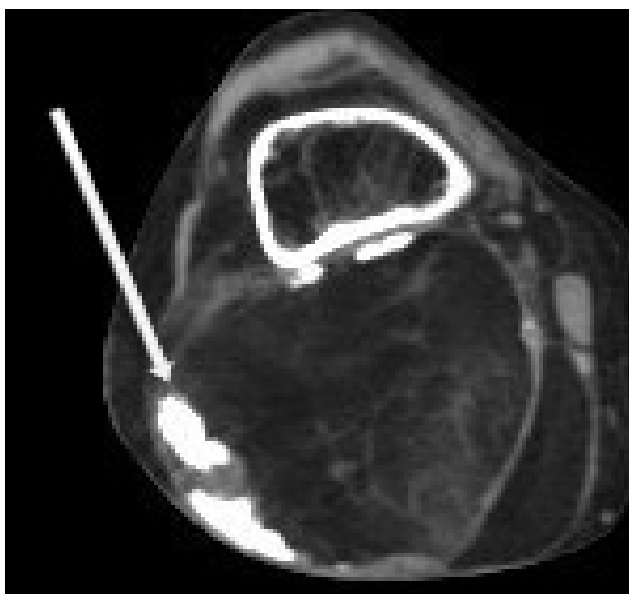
Axial computed tomography image shows central fat and peripheral calcification (arrow).
